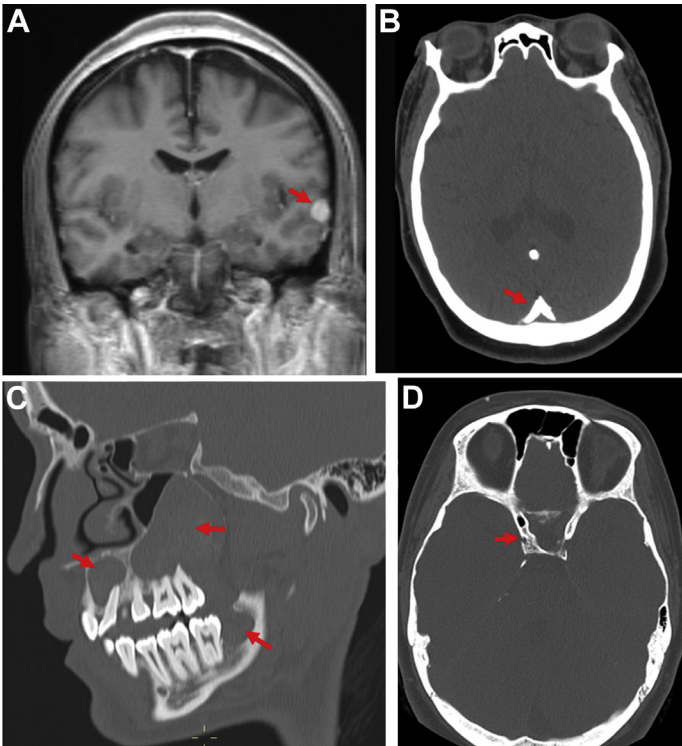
BCNS. (A) Coronal postcontrast T1WI shows a meningioma in left temporal convexity (*arrow*) in a 30-year-old patient with BCNS. (B) Axial CT head shows dural calcifications (*arrow*) in the same patient. (C) Sagittal oblique reformat of CT face of a 26-year-old patient with BCNS shows multiple OKCs in maxilla and mandible (*arrows*). (D) Axial head CT in the same patient shows sellar bridging (*arrow*).
